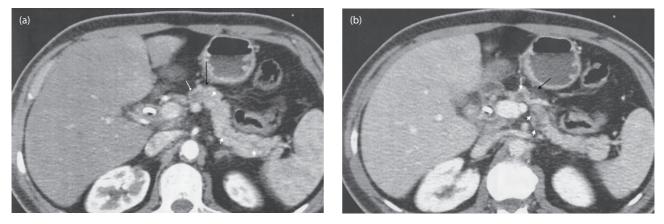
Transverse (a) arterial and (b) portal phase computed tomography (CT) images demonstrated interruption of the pancreatic duct in the neck portion along with downstream (white arrow) and upstream pancreatic duct dilatation (arrowheads). Images did not provide visualization of the mass (black arrow).
